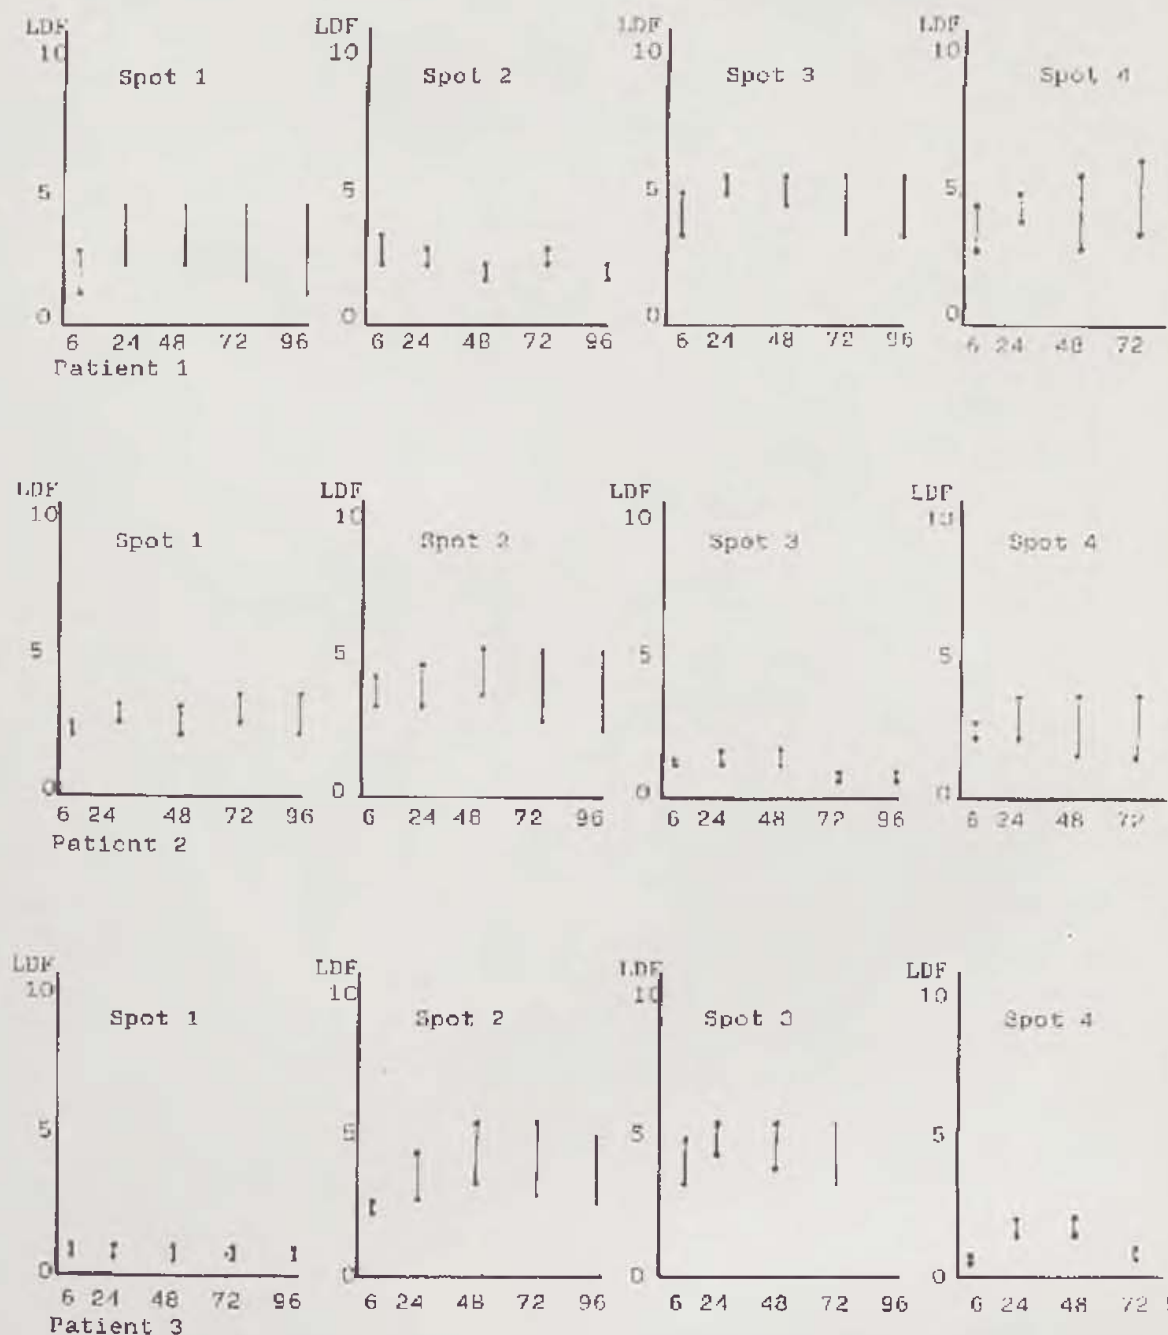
Four spots of 3 patients with laser Doppler flow values recorded on hour 6-96 post burn. Lower dots represent basic flow values and upper dots represent local heat stimulated values.
